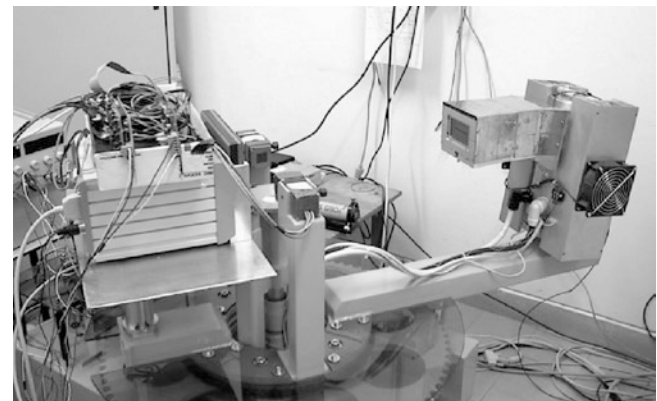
Prototype of a breast-dedicated SPECT/CT scanner (reproduced from: Gambaccini M, Fantini A, Bollini D, Castelli E, Del Guerra A, Di Domenico G, et al. Development of a quasi-monochromatic CT system for breast cancer study with combined emission-transmission tomography. *IEEE Trans Nucl Sci*. 2001;48:703-6, Figure 2)
